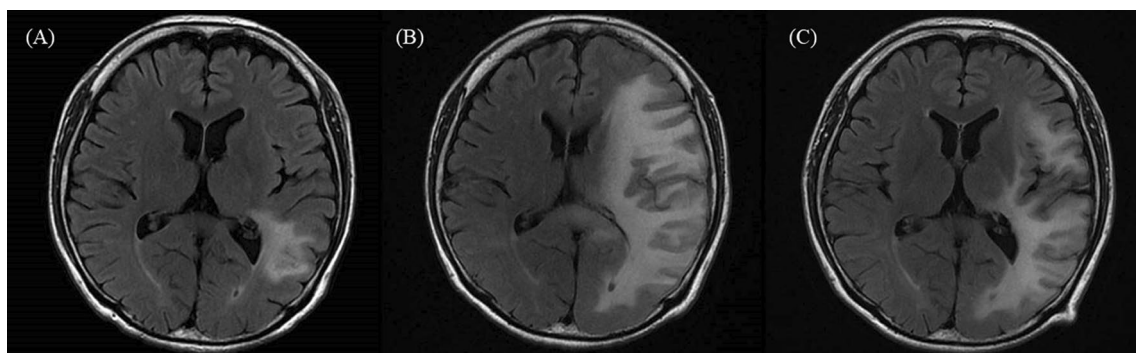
Magnetic resonance images of the head of the present case. A At the time of diagnosis. B At onset of seizures 41 days after the diagnosis. C 176 days after the diagnosis and 130 days after initiation of the treatment with mirtazapine
